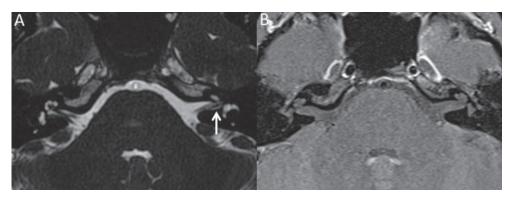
Vestibular ganglion in a patient with left sensorineural hearing loss. Axial T2-weighted magnetic resonance image (MRI) of the internal auditory canal (A) showed a small fusiform lesion along the left superior vestibular nerve. Subsequent contrast-enhanced MRI in T1-weighted sequence (B) showed no enhancement in the left internal auditory canal that confirmed the diagnosis of vestibular ganglion.
